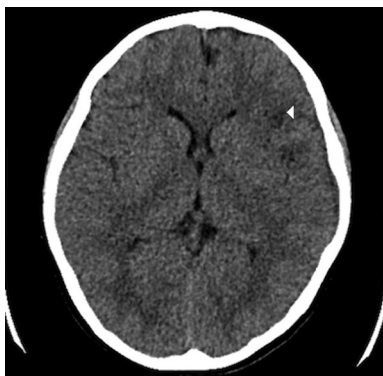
Axial non-contrast computed tomography of the head demonstrating a small left middle cerebral artery distribution hypodensity denoted by the white triangle in frontal white matter.
